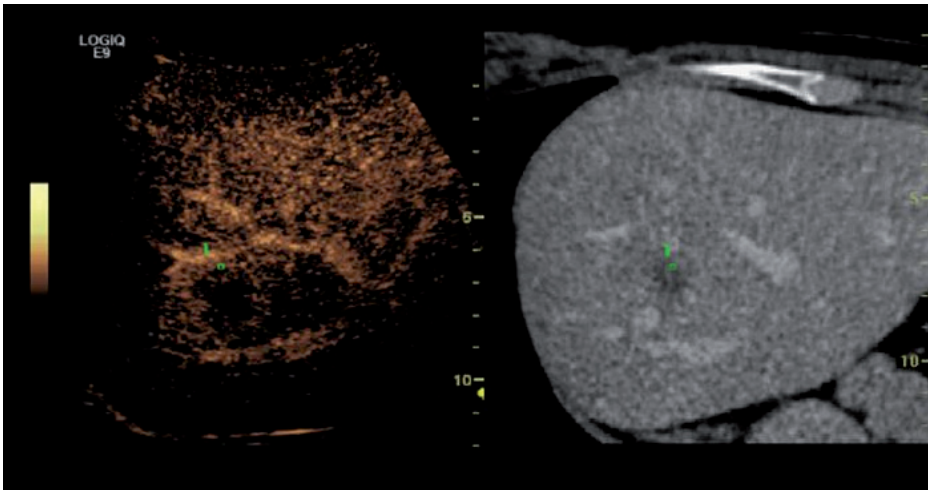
Image fusion can be implemented with complex ultrasound data, including contrast-enhanced ultrasound data. The segment VII lesion can be tagged by a GPS Target and identified using both types of imaging.
